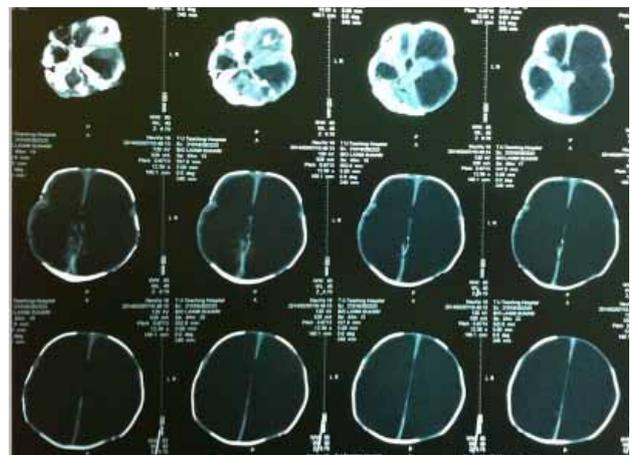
Plain CT head showing near absence of cortical mantle with remnants in frontal and temporal part suggestive of hydranencephaly
